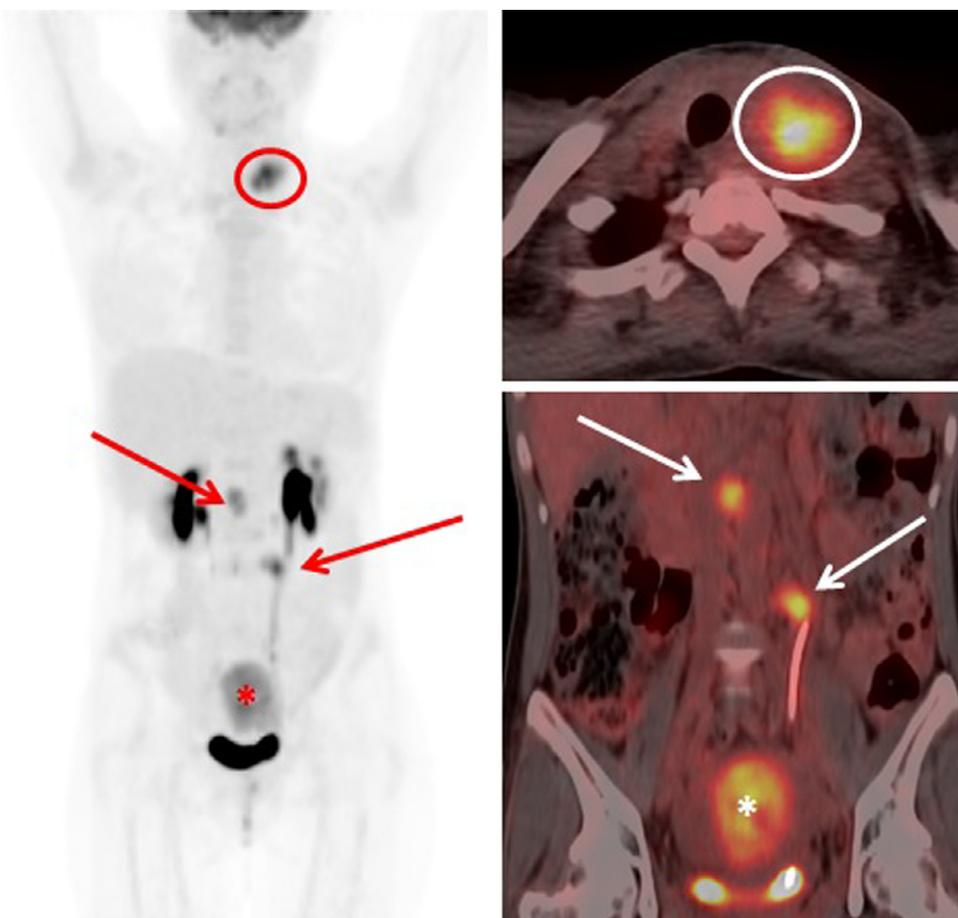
Recurrence post chemotherapy: 40 year old with previous locally advanced cervical cancer, treated with chemoradiotherapy, presented 1-year post treatment with new palpable left supraclavicular nodes. An FDG PET/CT performed for restaging confirms intensely metabolically active left supraclavicular nodal disease (circle) but in addition new local recurrence at the cervix (*) with multiple avid retroperitoneal and pelvic nodes (arrows). FDG PET/CT can be utilized in re-staging/recurrence imaging to assess extent of disease to help guide subsequent treatment options in cases when surgery would be futile.
